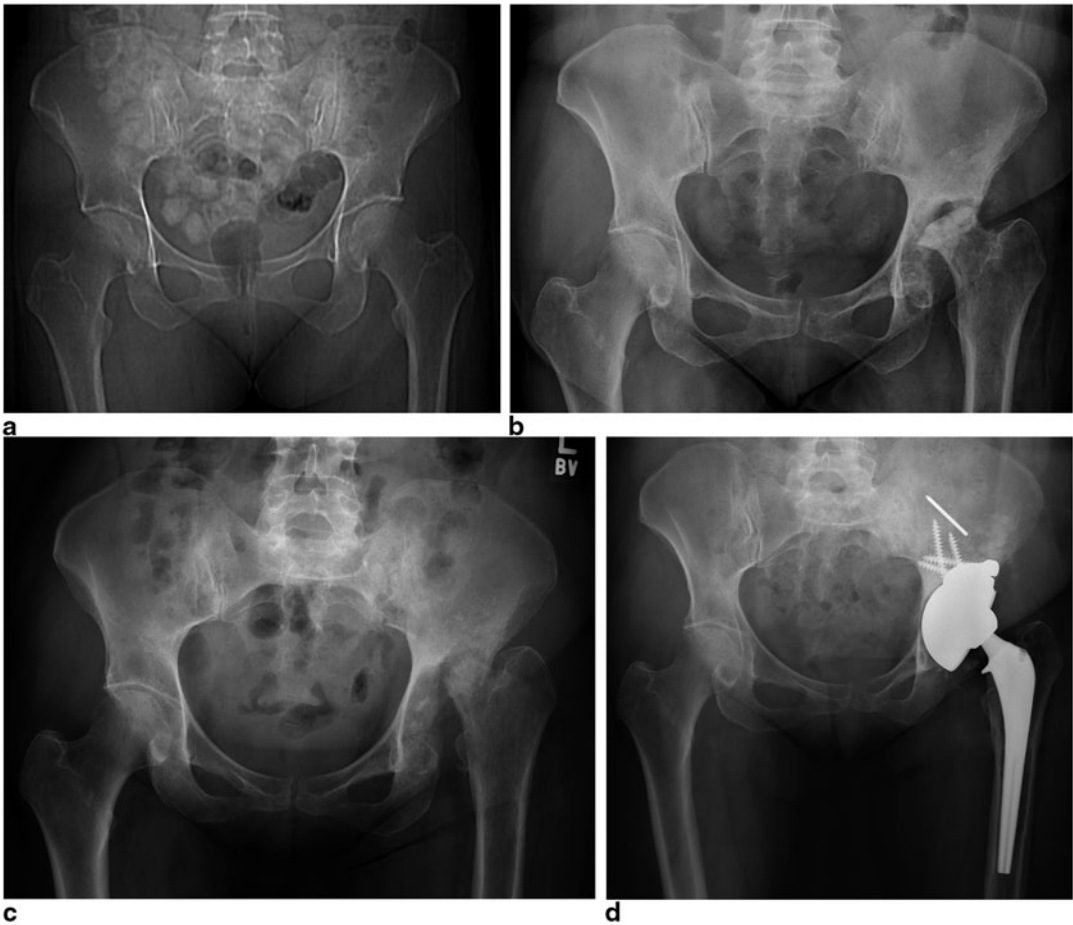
Femoral head osteoradionecrosis with progressive excavation of the hip joint treated with THA. 51-year-old female with history of T2n0m0 squamous cell carcinoma of the anal canal status postexternal beam radiation therapy with implant boost received a total dose of 45 Gy. a Scout radiograph of the pelvis in the anteroposterior projection from a CT scan obtained 8 months after completion of radiation therapy demonstrates preservation of the bony mineralization and no fractures or dislocations. b Anteroposterior radiograph of the pelvis obtained 13 years after the completion of radiation therapy demonstrates interval near total destruction of the femoral head
